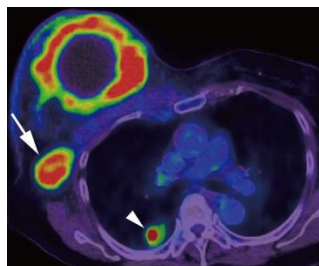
MRI image with lung metastases in the right breast (Koh & Kim, 2019).
